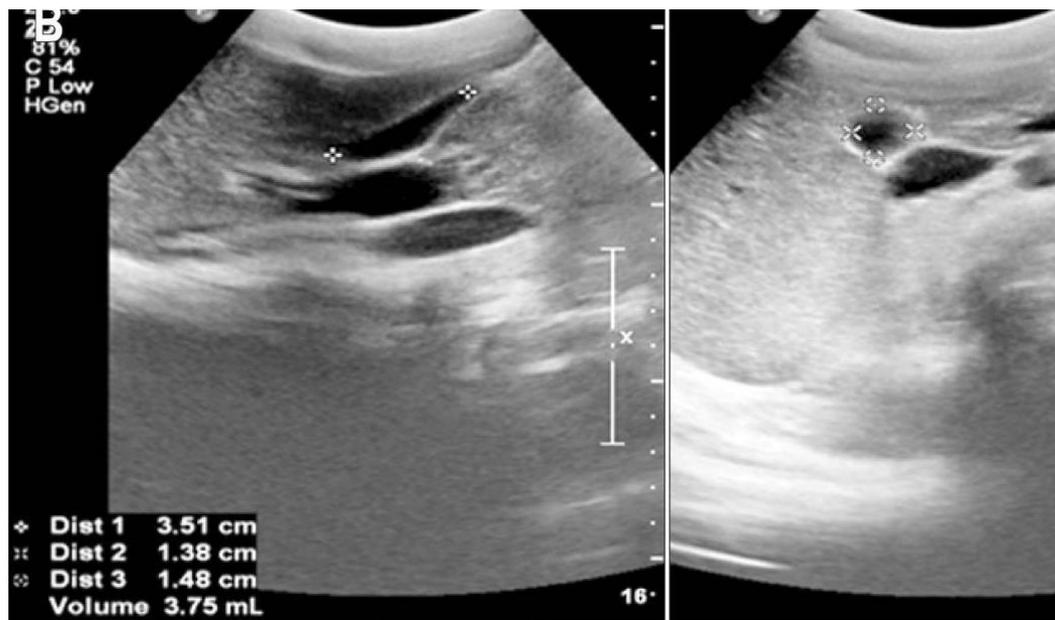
Calculation of gallbladder volume on ultrasound in two longitudinal (left) and transverse (right) sections
